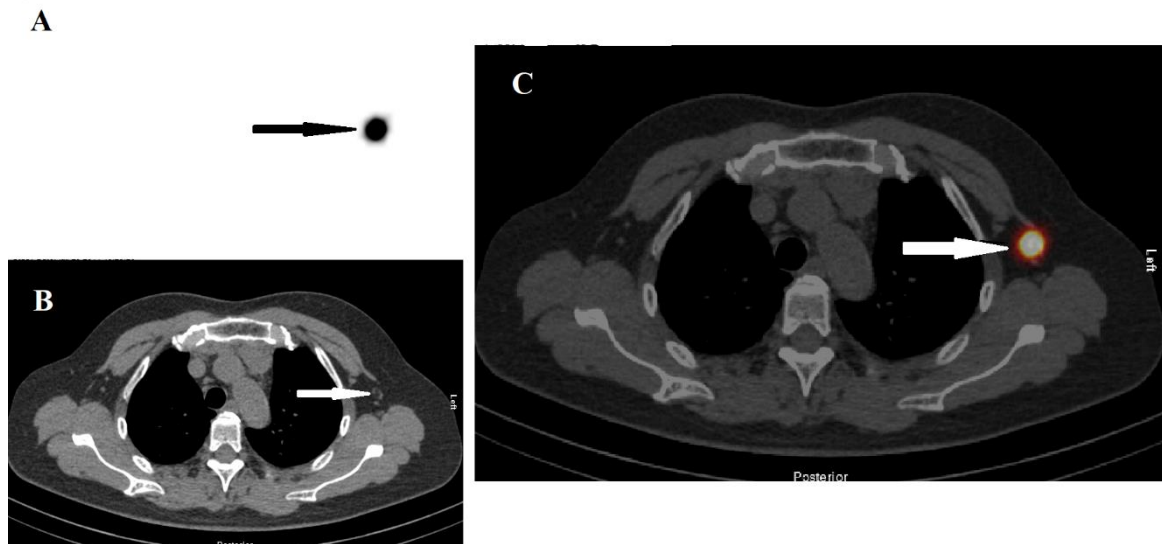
SPECT/CT lymphoscintigraphy of patient undergoing pre-operative Sentinel Lymph Node evaluation of the left breast. A) transversal SPECT images B) transversal CT images C) transversal hybrid SPECT/CT images. Arrows indicate Sentinel Lymph Node uptake in SPECT images and the anatomical location of the SLN in CT images.
